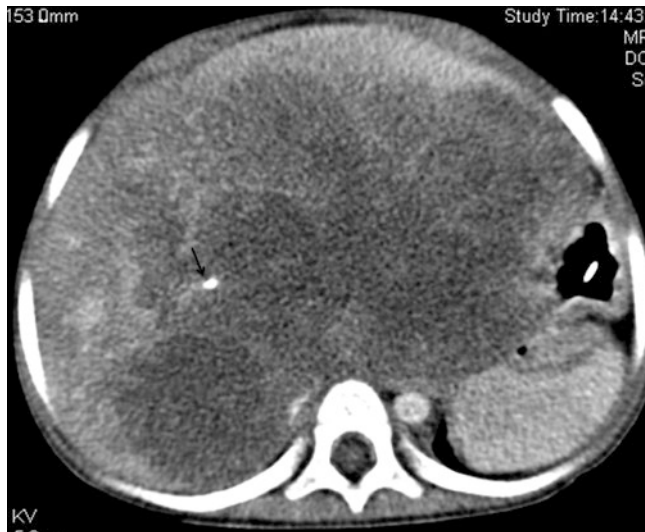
A CT scan performed on the portal venous phase shows a large, poorly enhancing hepatoblastoma involving the whole of the liver; note intralesional calcification (*arrow*)
